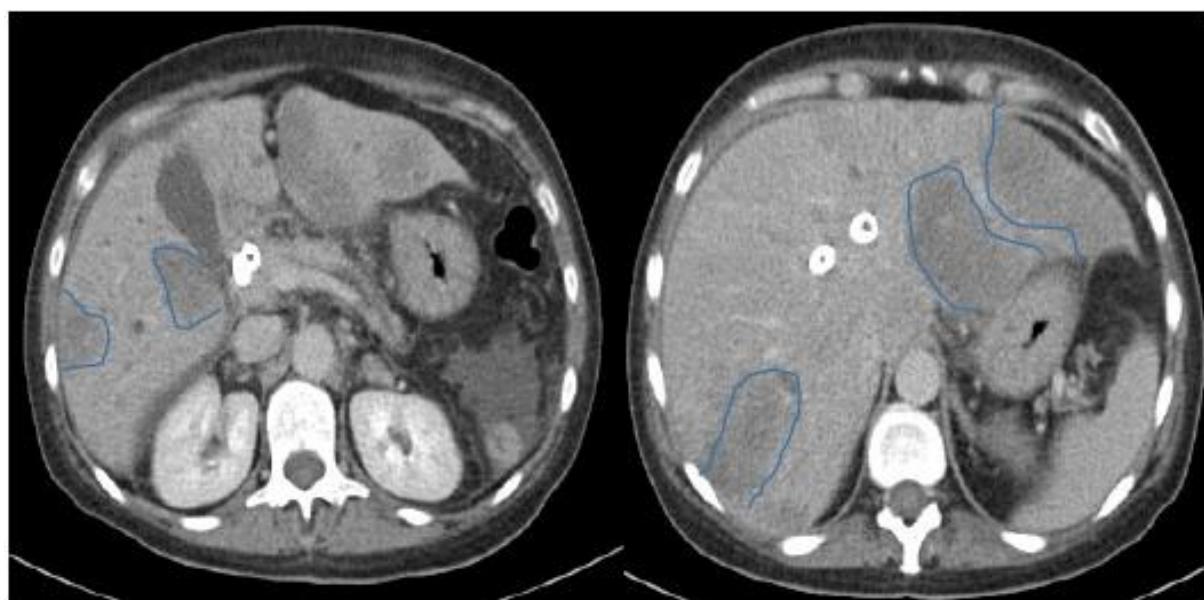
CT-scan shows hypodense lesions, Metastatic-like lesions.
